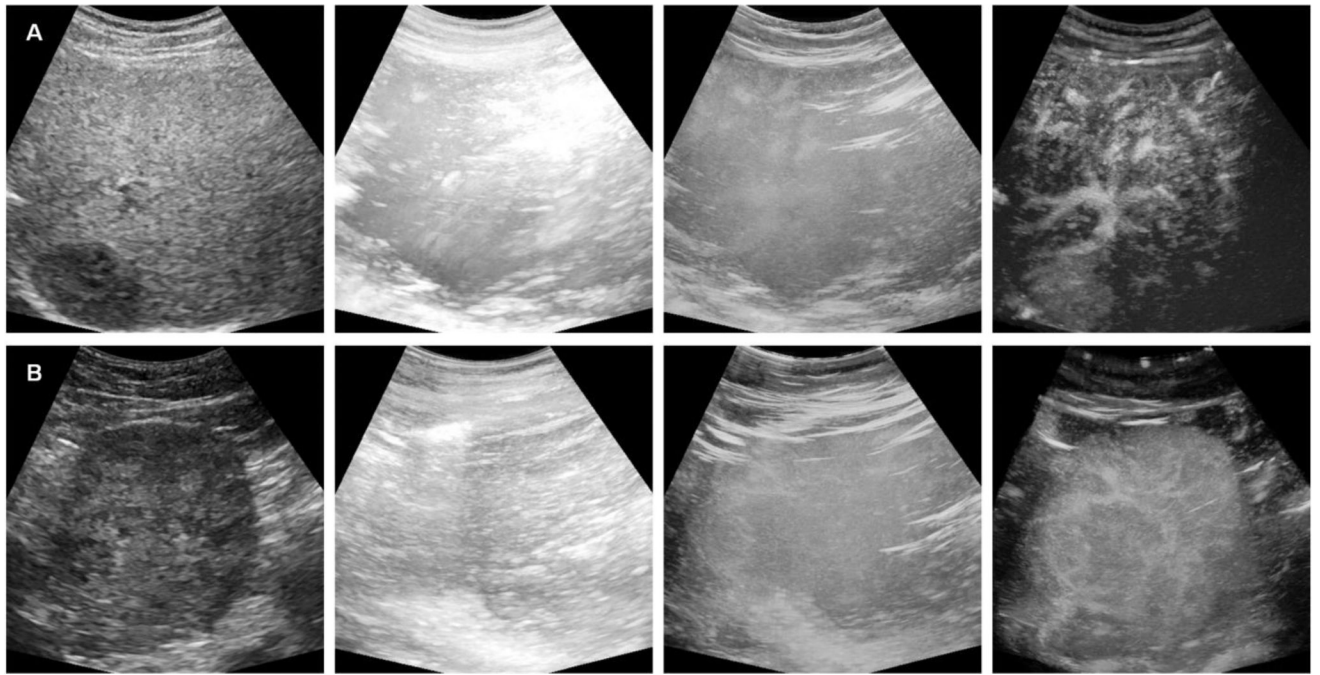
Representative ultrasound (US) results from patients with HCC determined to have either a complete (top) or incomplete (bottom) response to TACE treatment. As shown from left to right are the B-mode US image, maximum intensity projection (MIP) of the original B-mode US, CEUS image, and MIP of the motion corrected CEUS image sequence.
